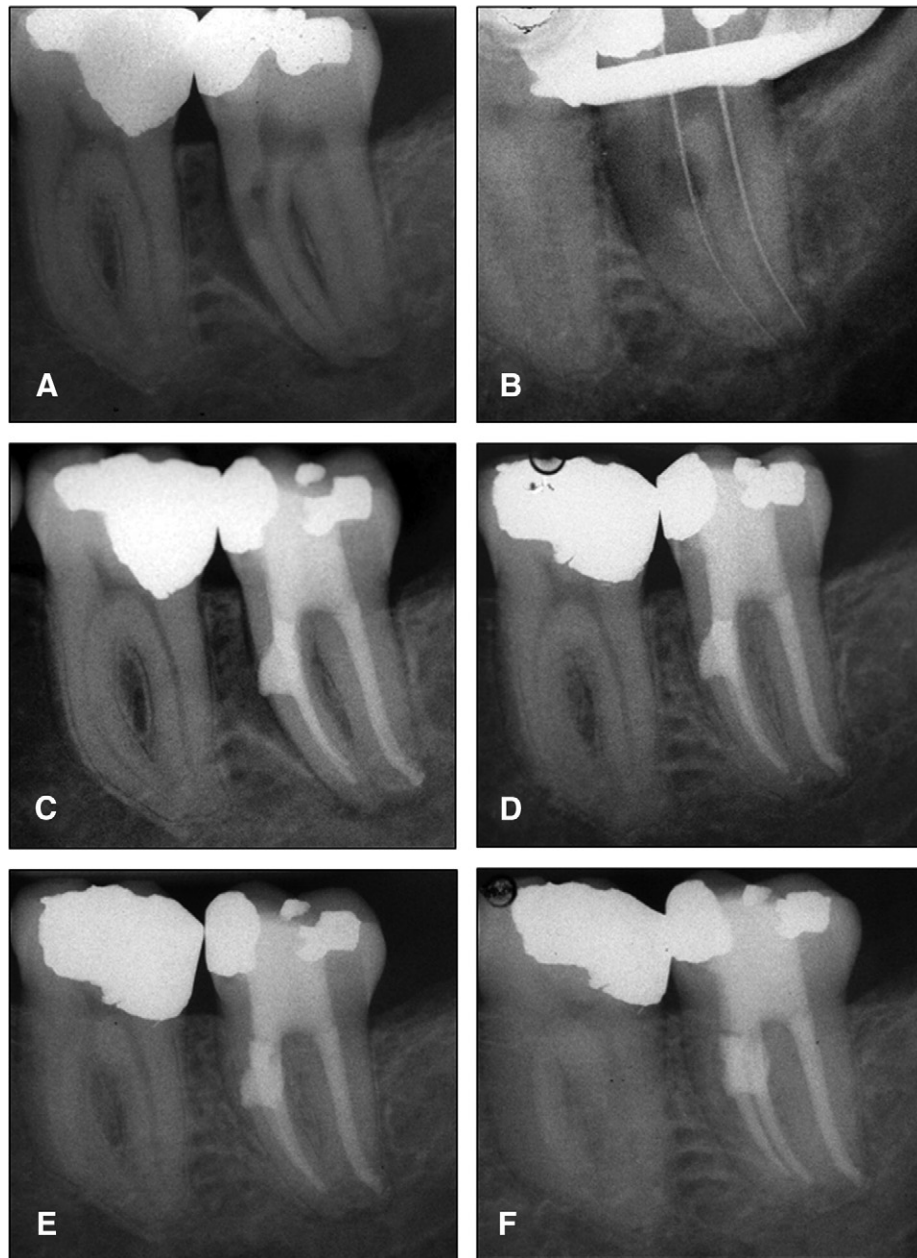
Periapical radiographs before, during, and after endodontic treatment of mandibular left second molar with internal resorption in mesial root. (A) Preoperative radiograph showing crescent radiolucent lesion in the alveolar bone next to a resorptive lesion in the mesial root. (B) A radiograph taken to establish working length in mesiobuccal and distal canal. (C) A radiograph taken immediately after filling of the resorption space with MTA and obturation of the root canals with gutta percha and sealer by hybrid condensation. (D) Eleven-month follow-up: healing of the mesial bone lesion is evident. (E) Two-year follow-up shows complete resolution of the radiolucency. (F) Distally angulated radiograph at 2-year follow-up.
